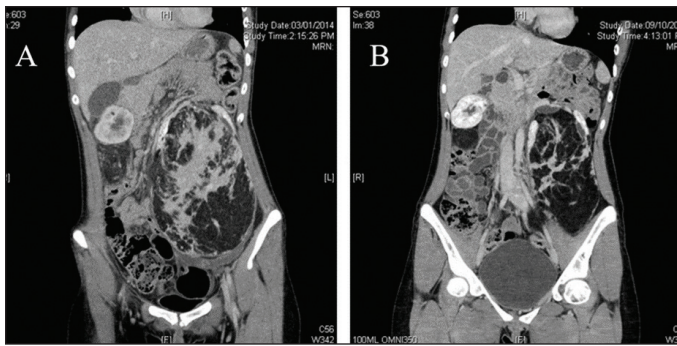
(A) Contrast abdominal computed tomography showing 13.2 cm left renal angiomyolipoma (AML) with acute bleed. (B) AML decreased in size to 9.6 cm after nine months of everolimus therapy.
